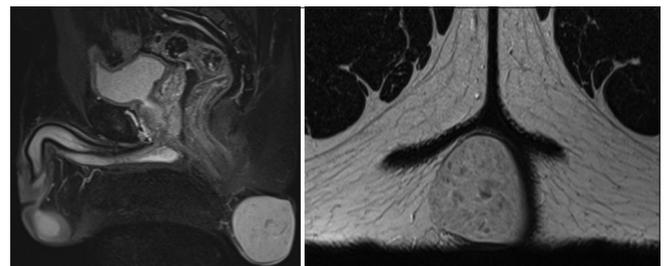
Magnetic resonance imaging pelvis of the perianal swelling
